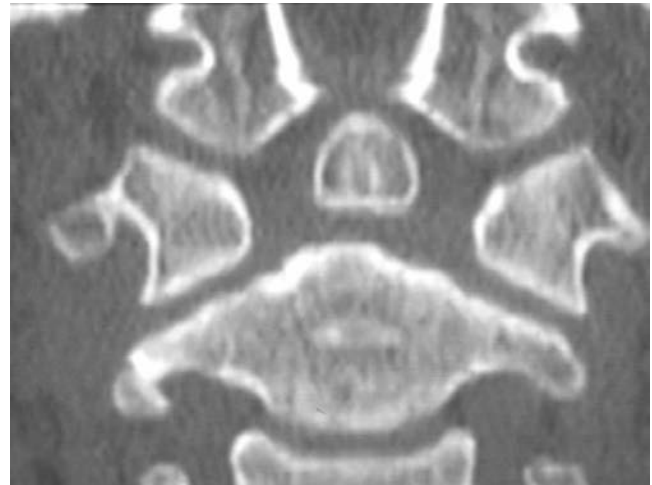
CT scan showing presence of an os odontoideum. Note the position of the os well above the C1 to C2 facets. The scan also shows the vestigial scar of the synchondrosis between the dens and the body below the C1 to C2 facet.
